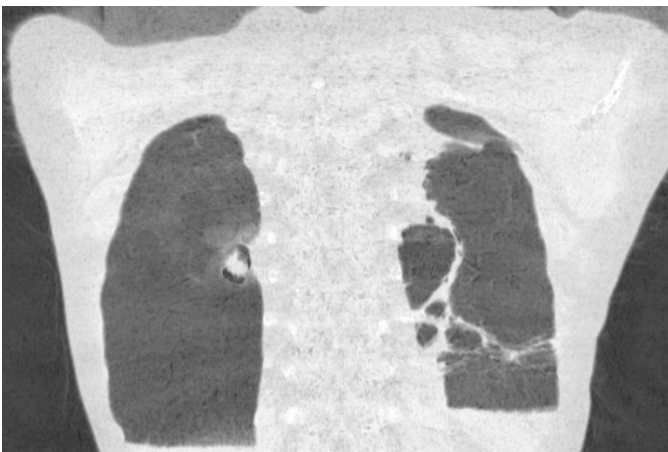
Figure c: CT thorax – shows Resolution of atelectasis of left side and Cylindrical Dilatation with large mucus Plug in the Right lower lobe.
